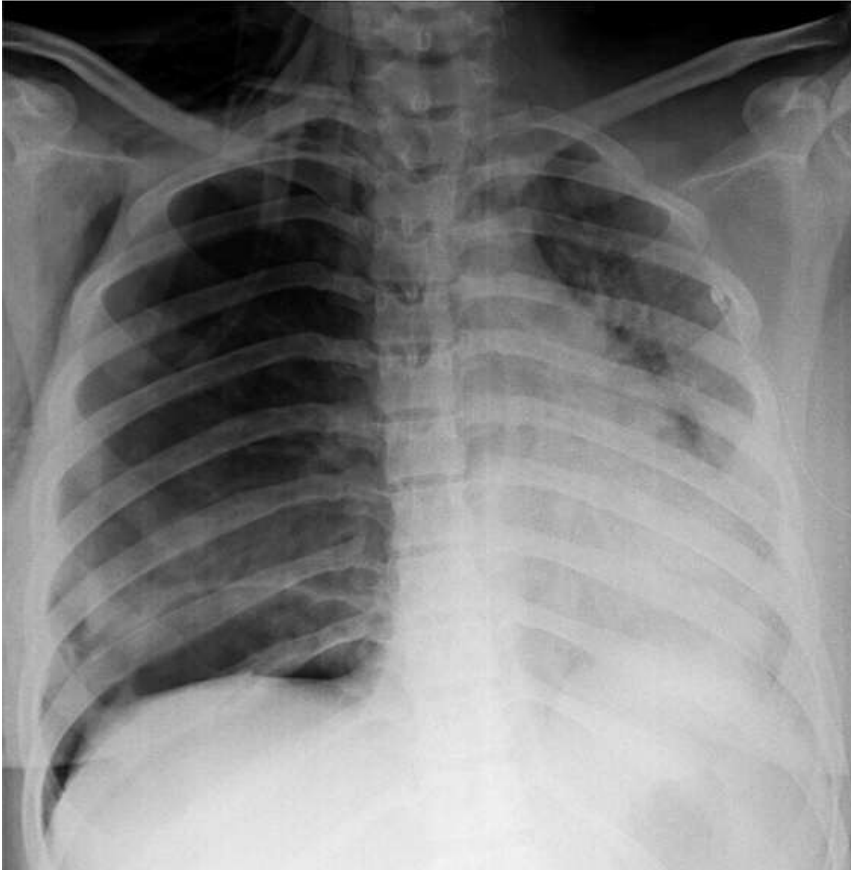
frontal chest X-ray showing left alveolar condensations with difference in transparency on the right side
